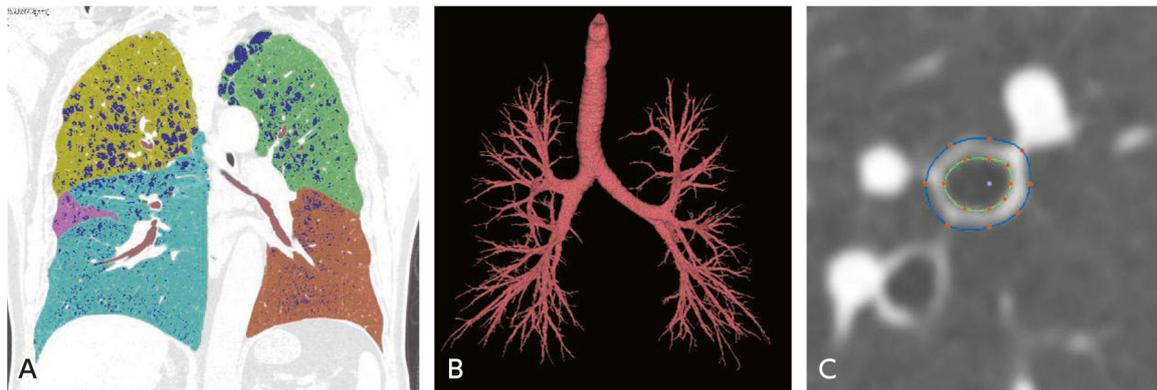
Examples of CT quantitative evaluation of COPD
